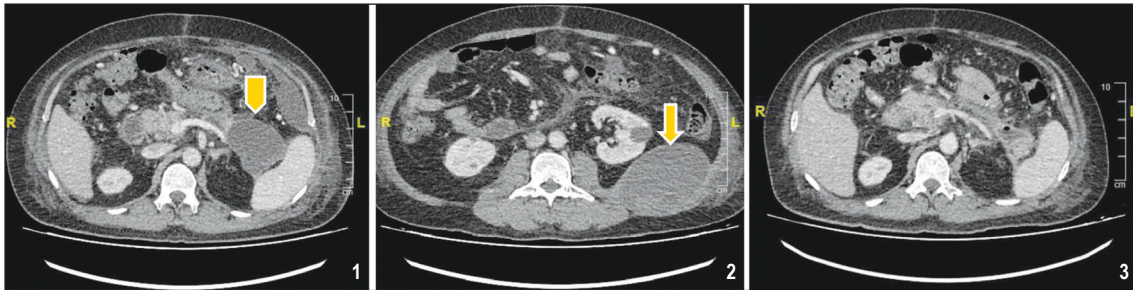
Figure 1 (left): Pancreatic collection at the tail. Figure 2 (right): Collection extending craniocaudally and confines within the anterior pararenal space and tracking posteroinferiorly, splitting the posterior perirenal fascia medially. Figure 3 (below): CT taken 2 weeks after the USG guided drainage showed reduction in collection and currently measures 5.0 cm (previously 8 cm) in widest diameter and 11.6 cm craniocaudally (previously 20 cm).
